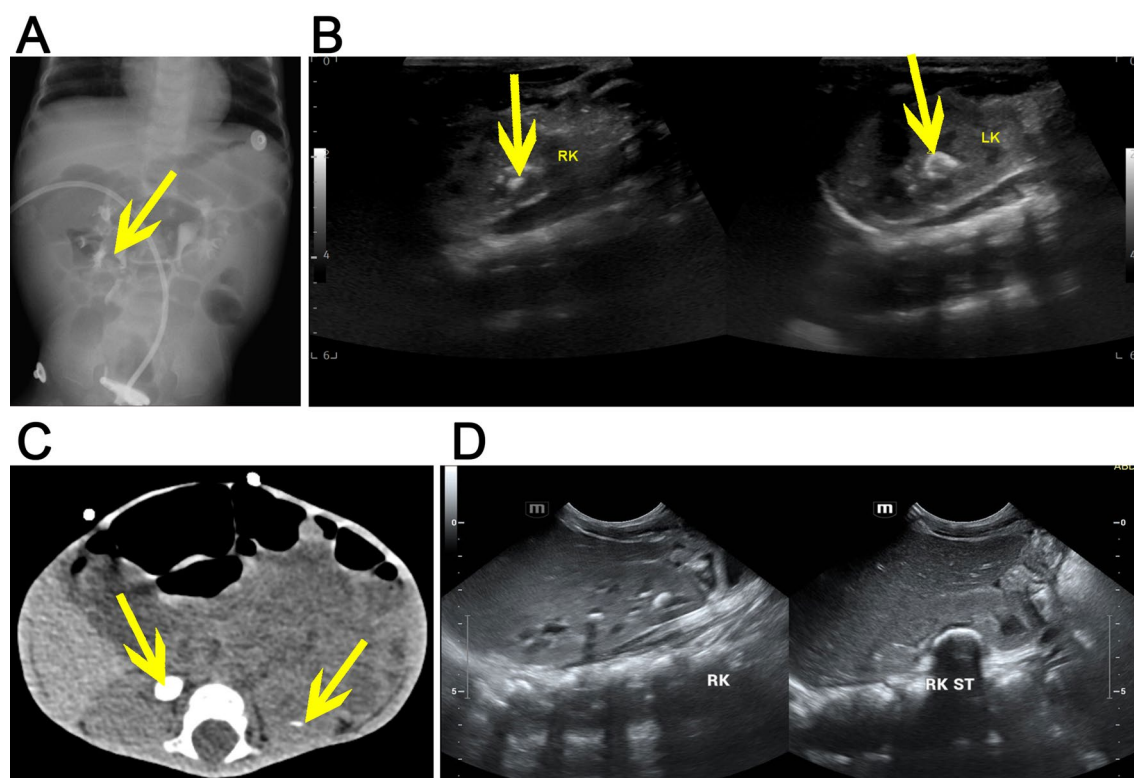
Imaging findings of the patient. (A) Intravenous pyelography showing right renal pelvic filling defect, suggesting renal pelvic calculi. (B) Renal ultrasound showed kidney stone in the left kidney and right kidney. (C) CT scan showed renal calculi. (D) Renal ultrasound showed multiple renal calculi in the right kidney with acoustic shadowing and larger stones in the right kidney with acoustic shadow
